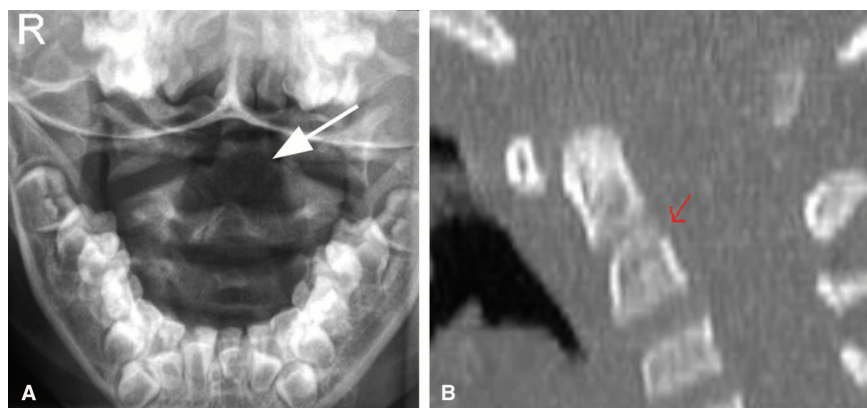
A, Initial odontoid view radiograph obtained at the emergency department is suggestive for a C2 fracture, depicted by the arrow. B, Computed tomographic scan confirmed a type III odontoid fracture without angulation or displacement.
